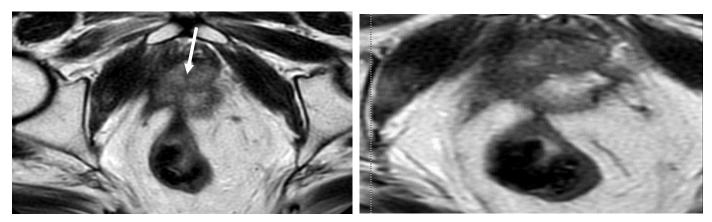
Axial MRI T2 weighted images post-radiotherapy of a case of advanced hormone-sensitive prostate cancer.
